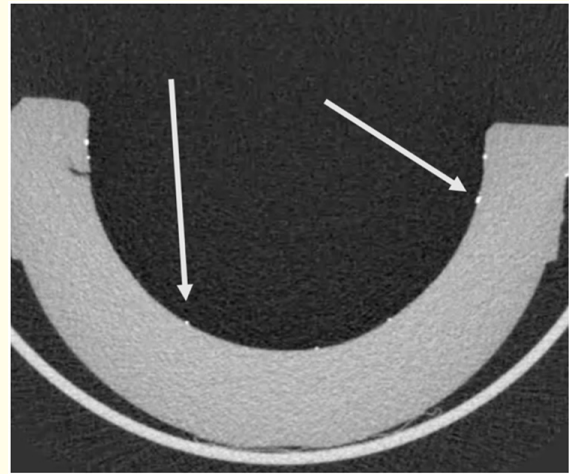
CT scan showing embedded ceramic particles (arrows) in the liner
